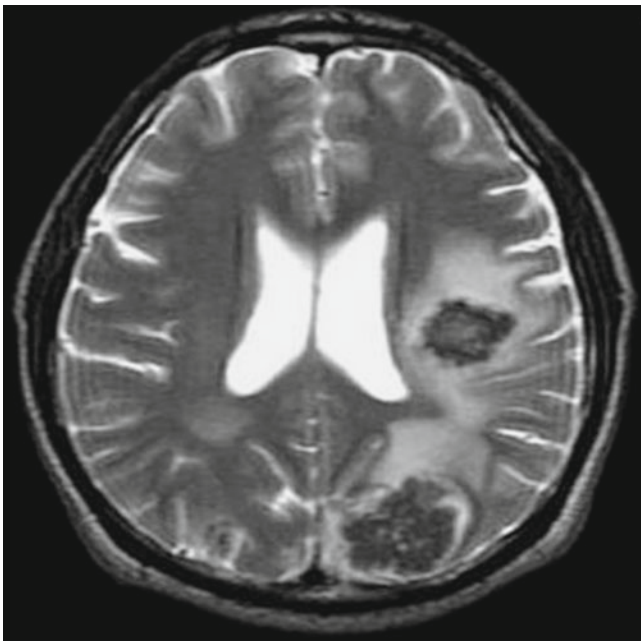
Cerebral alveolar echinococcosis. MR imaging demonstrates multiple irregularly shaped lesions in the brain, mostly with low T2WI signal and surrounded by edema with high signal
